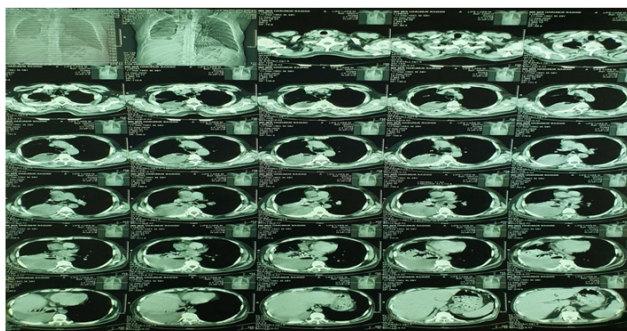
CT scan chest shows right sided encysted Hydropneumothorax.
